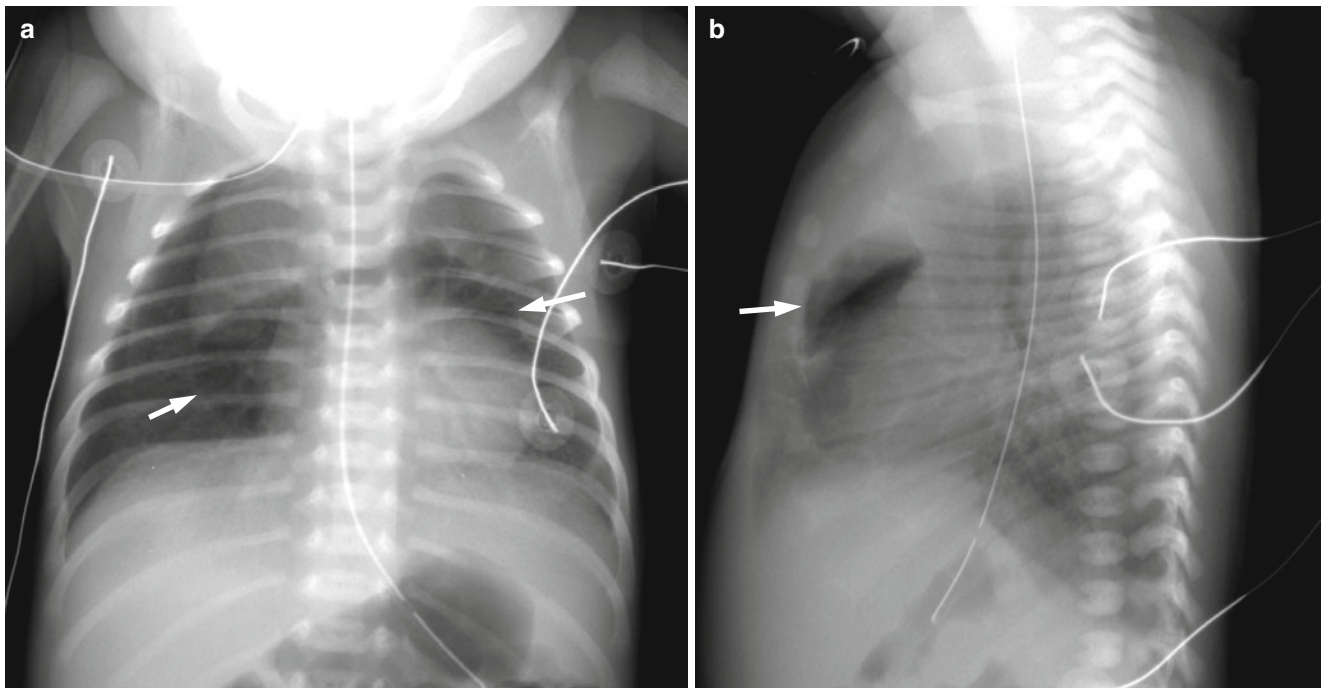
Pneumomediastinum. Frontal and cross-table lateral chest radiographs show elevation of the thymus by a large central lucent area (mediastinal air, *arrows*)
